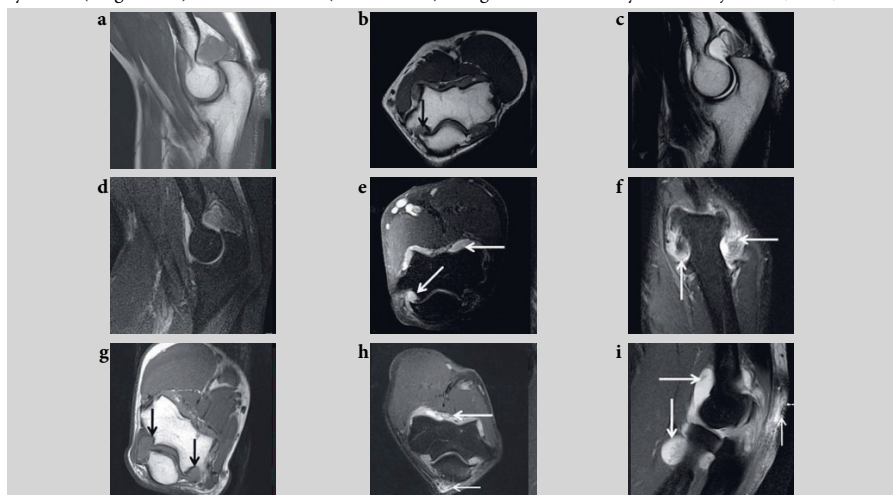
Magnetic resonance imaging (MRI) of elbows of a patient with rheumatoid arthritis. (a–f): Left elbow. (a) Sagittal and (b) axial T1-weighted; (c) sagittal T2-weighted; (d) sagittal and (e) axial T1-weighted fat suppressed post-contrast; (f) coronal short tau inversion recovery (STIR) MRI sequences. Images show massive synovitis (thick white arrows) and erosion in the lateral humeral condyle (black arrow). (g–i): Right elbow. (g) Axial T1-weighted; (h) axial STIR; (i) sagittal T1-weighted fat-suppressed image after intravenous contrast injection. Massive synovitis (thick white arrows), erosion in the medial and lateral humeral condyles (g; black arrows), and bursitis olecrani (e, f, h, i; thin white arrows).
